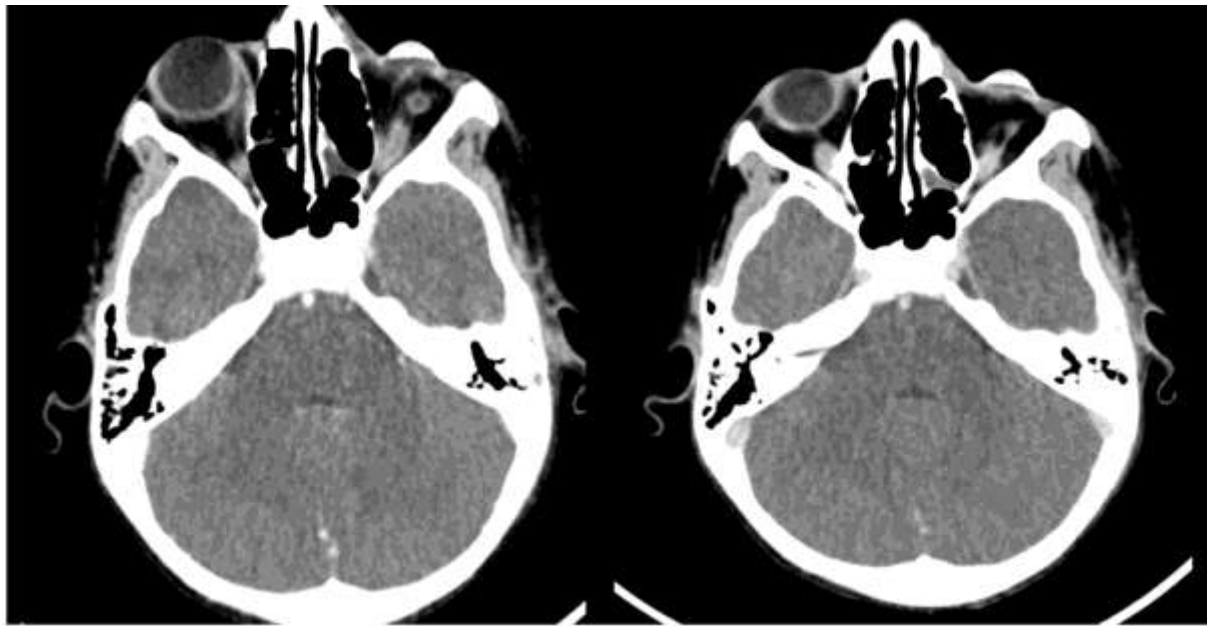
Axial CT images post radiotherapy showing complete clinical response.
